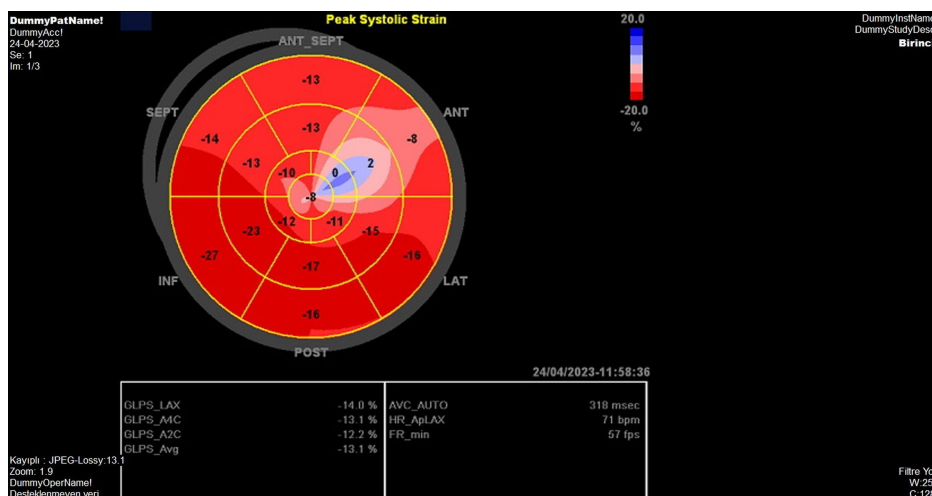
The 2D strain transthoracic echocardiography at the 72nd hour showed an improvement in the left ventricular systolic functions.
